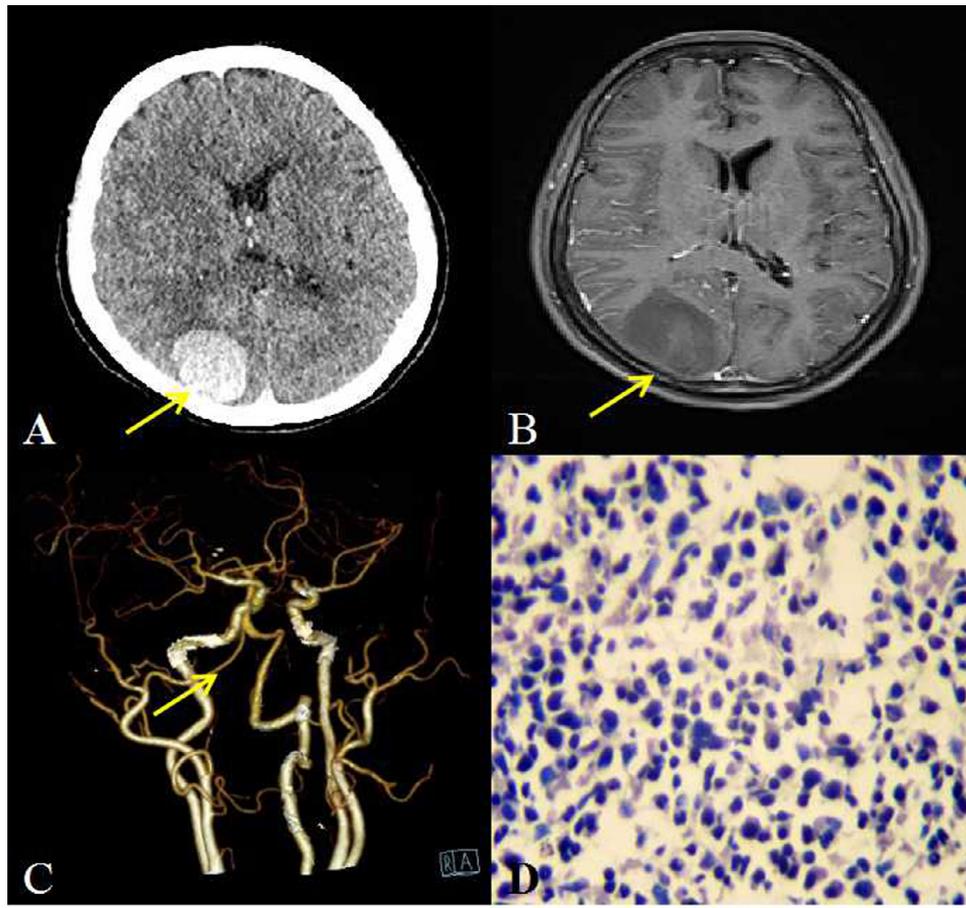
(A) Computed tomographic (CT) showing the high density hemorrhage lesion in the parietal and occipital lobe. (B) Gadolinium-enhance magnetic resonance displaying no enhancement around the lesion. (C) CT angiogram showing the physiologic angusty in right vascular vertebral artery of the intracranial segment but no cerebrovascular malformation. (D) Bone marrow biopsy showing active proliferation of bone marrow cells especially the erythrocyte series and megakaryocyte series.
